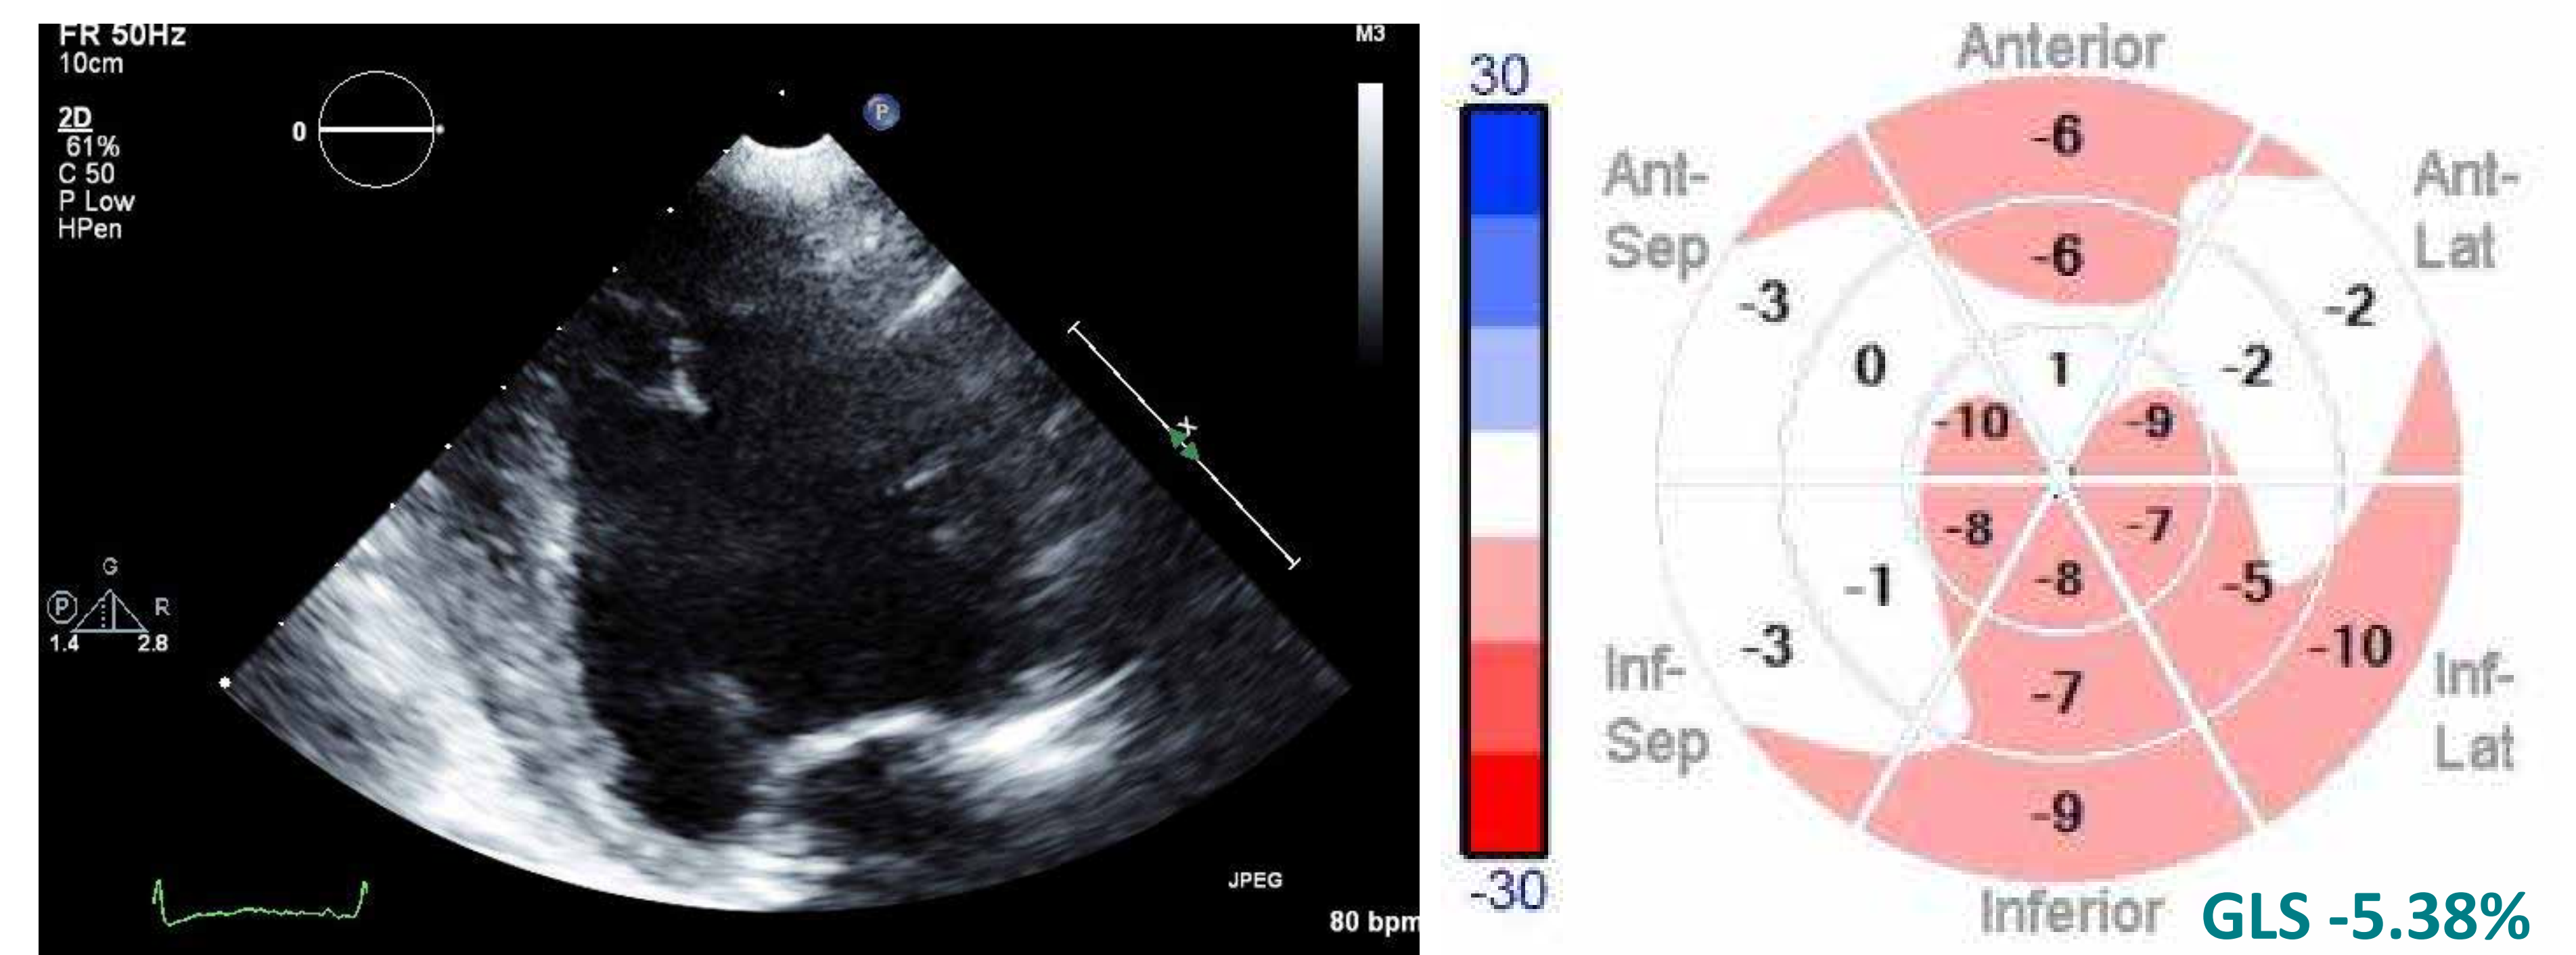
Apical 2C view showing no LV thrombus and 2D-STE strain showing sparing of apex and inferior walls.
